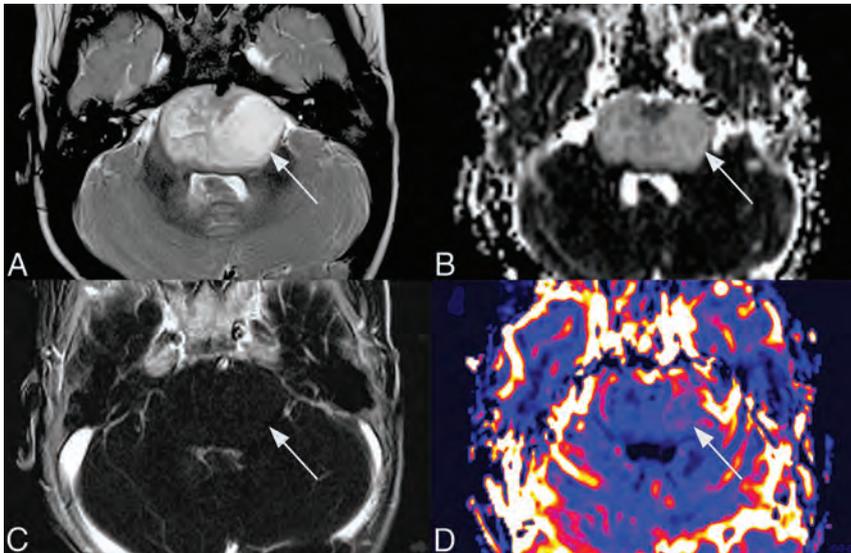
Axial MR images centered on the pons and showing non-necrotic $T2^{HrF}$ (long arrow). T2-weighted image (A), ADC map (B), T1-weighted postcontrast subtraction image (C), and CBV map (D). These images show a well-defined, fairly voluminous $T2^{HrF}$ within the left hemipons (a smaller similar lesion may be present on the right side, too), which is associated with mass effect, slightly increased signal in ADC (B), lack of contrast enhancement after IV gadolinium injection (C), and moderately increased CBV (D).
